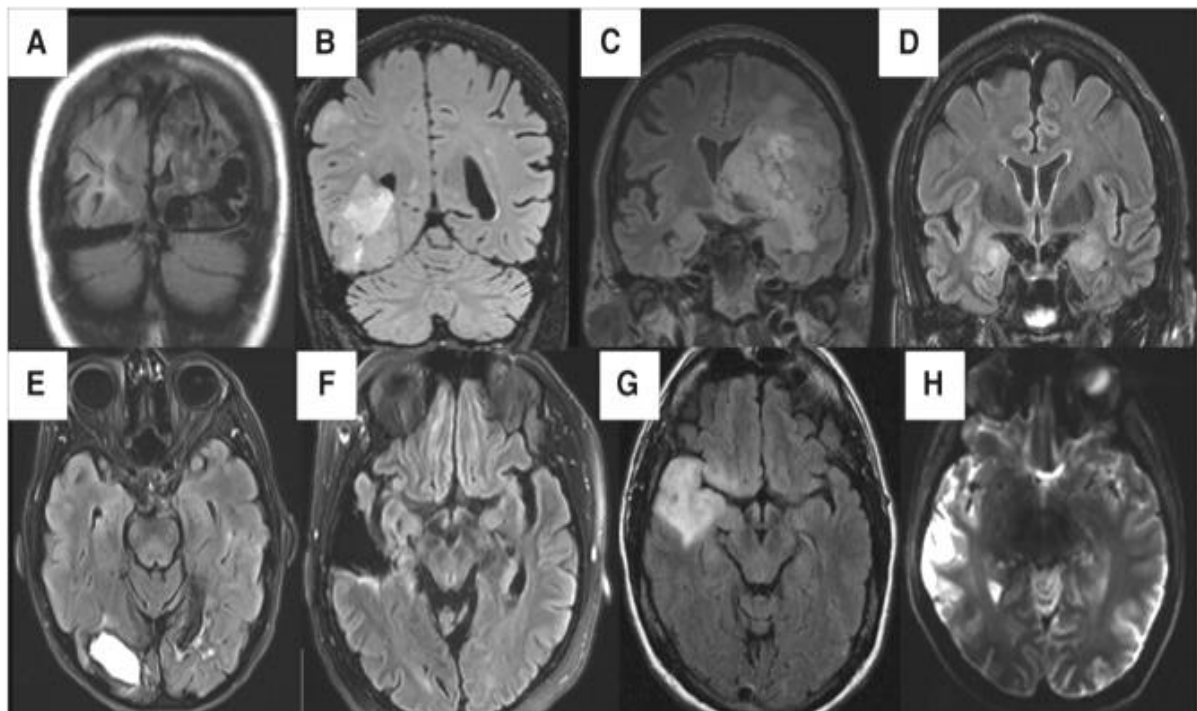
MRI scans showing structural abnormalities in individuals not diagnosed with dementia
